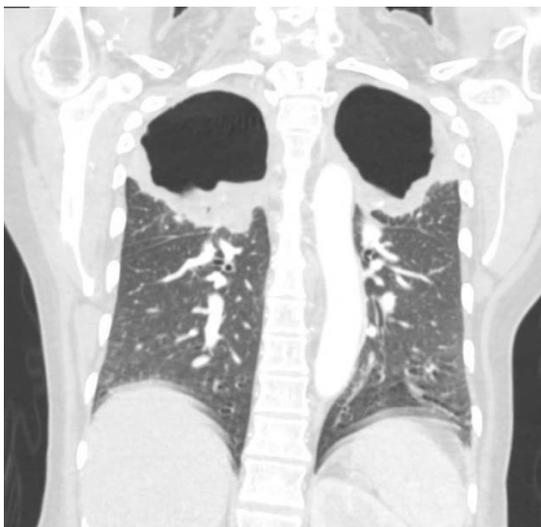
Coronal view of Chest CT showing two lobulated large perihilar cavitary lesions with thick walls involving bilateral apices with internal cystic components.
